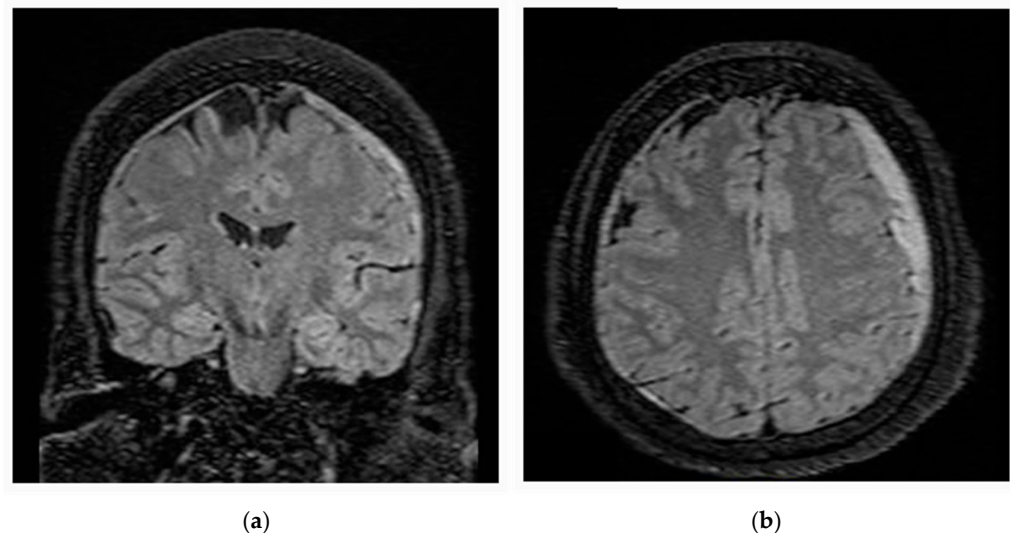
Brain MRI demonstrating findings consistent with intracranial hypotension. Axial (a) and coronal (b) magnetic resonance imaging of the brain demonstrate bilateral convexity SDH, greater on the left, with associated mild left-to-right midline shift. There is diffuse pachymeningeal enhancement, along with imaging features of intracranial hypotension including narrowing of the pontomesencephalic angle and reduced cerebrospinal fluid surrounding the optic nerve sheaths. No evidence of acute ischemia or intracranial mass is identified.
